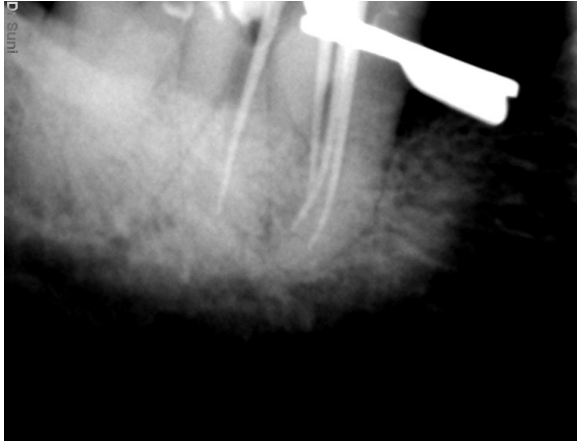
IOPA Xray shows 37 with master cones
